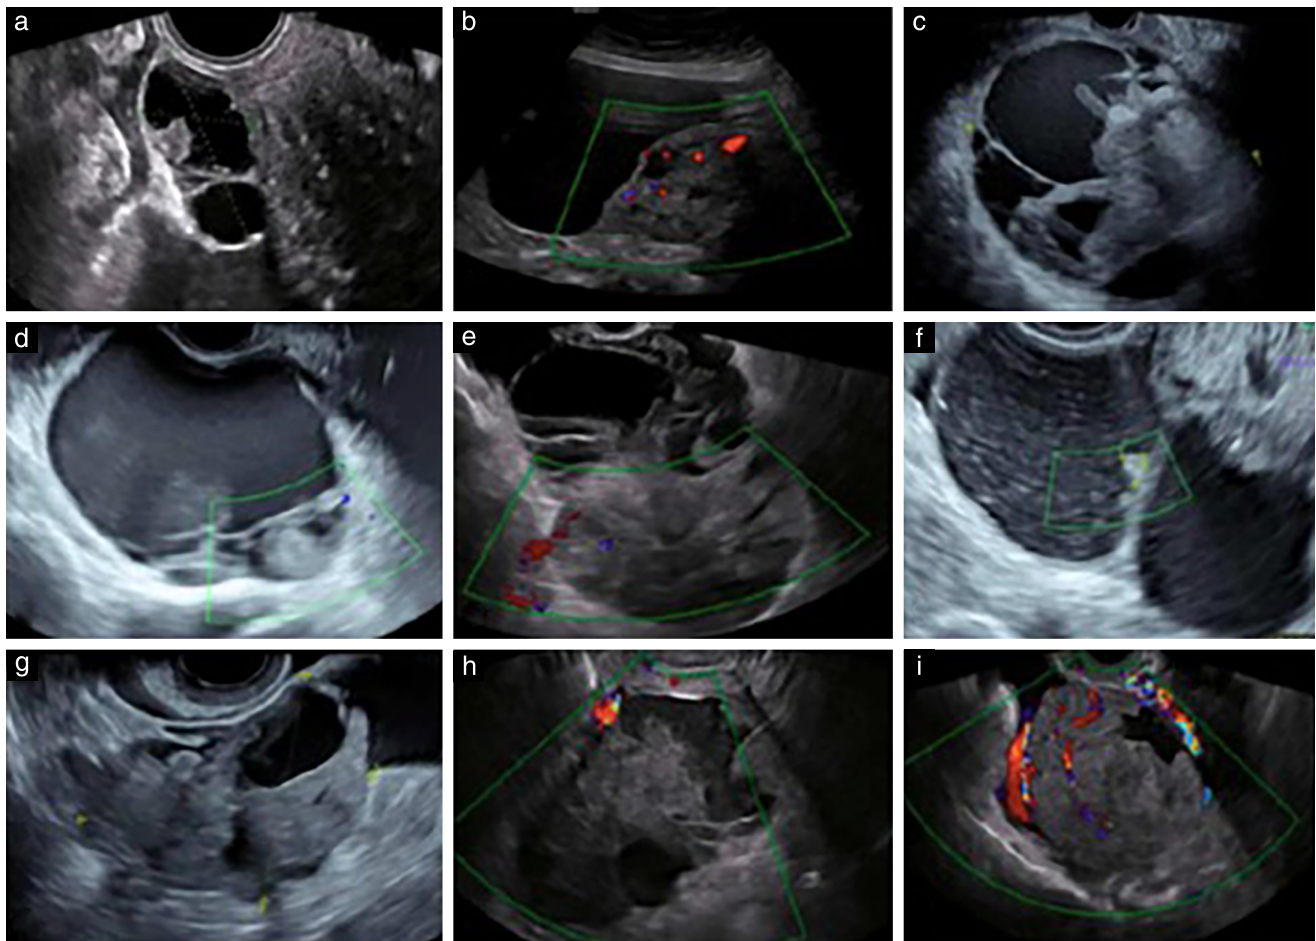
Ultrasound images of ovarian mass in patients with synchronous primary endometrial and ovarian cancers described as multilocular-solid (a–f) or solid (g–i) mass.
